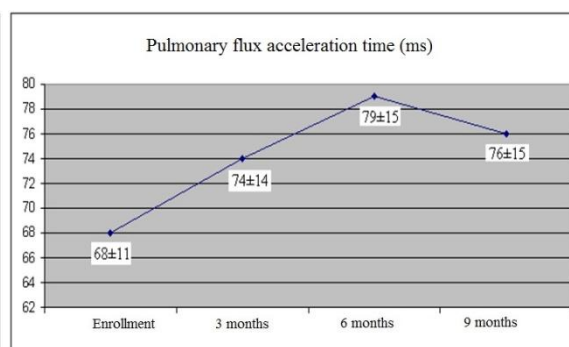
Evolution of the acceleration time of pulmonary flow determined by echocardiography, during the 9 months of monitoring.
